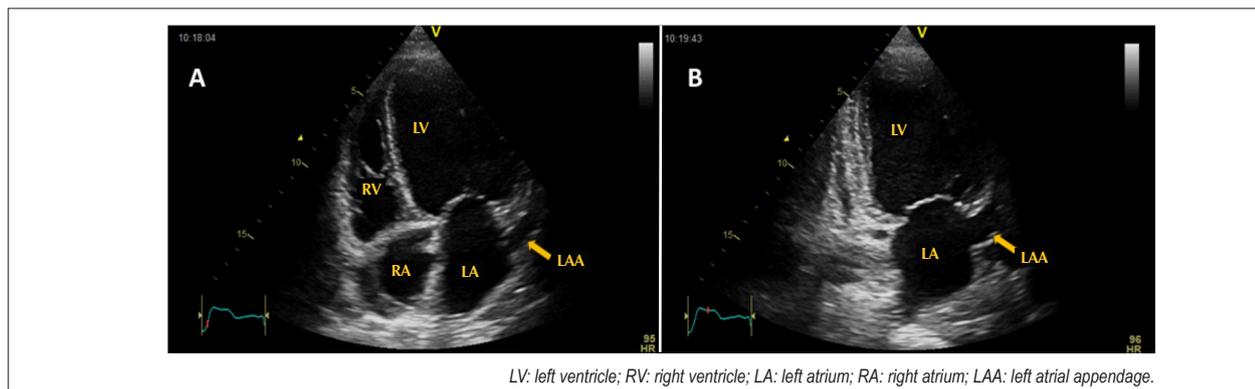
TTE showing the LAA in apical four-chamber (A) and two-chamber view (B).
